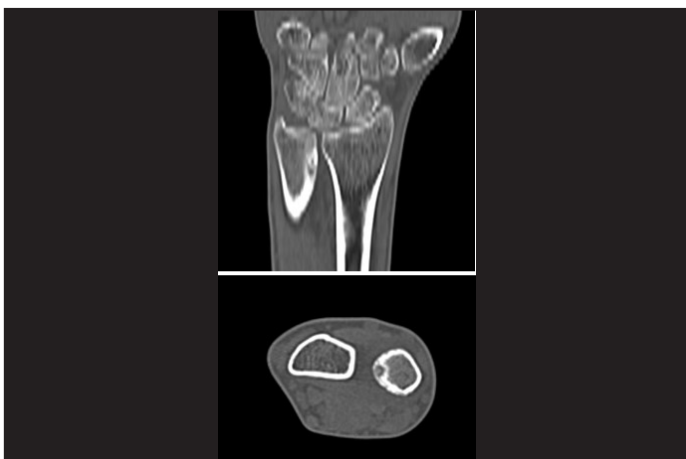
Computed tomography of the wrist. The lesion matching the nidus is selected in the distal ulna.
